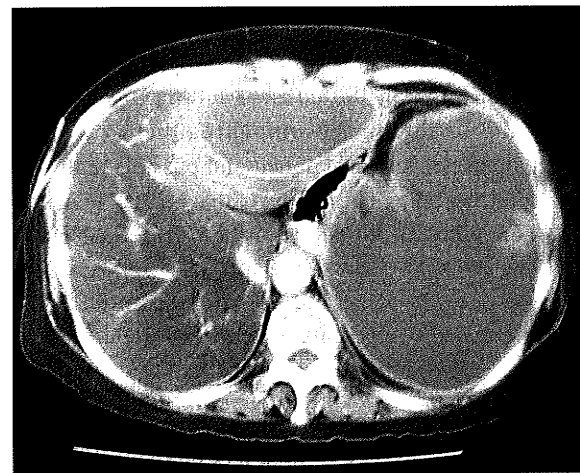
Enhanced CT of the upper abdomen. Posterior wall of the stomach (P) is marked.
